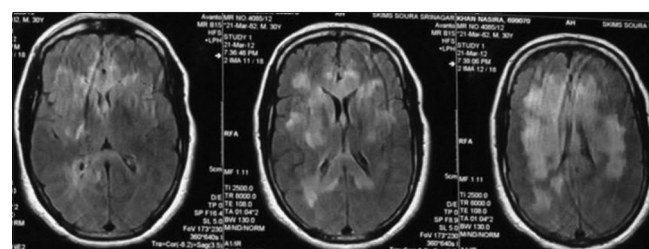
MRI brain with T2-weighted images
